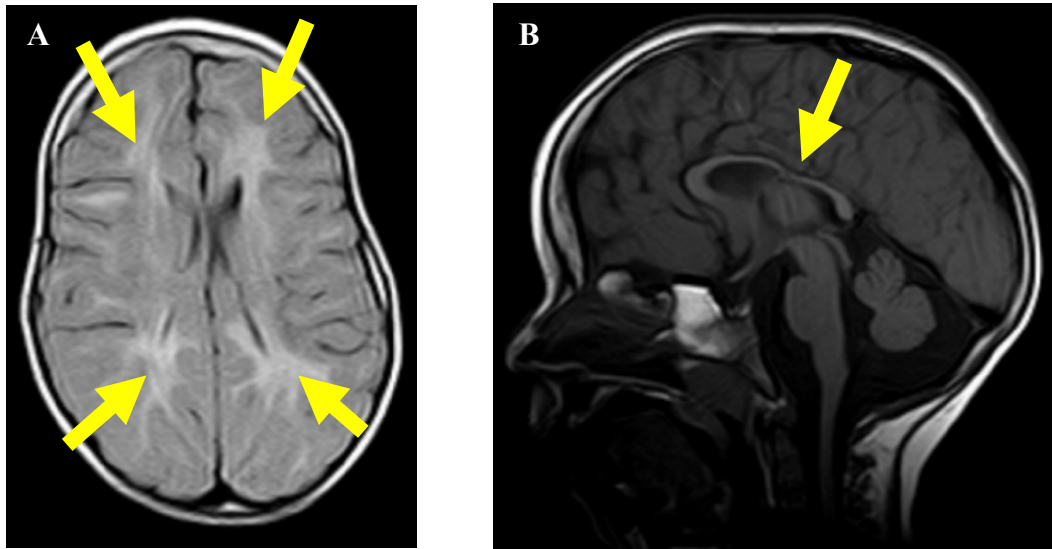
Brain MRI neuroradiological images for Patient 12
